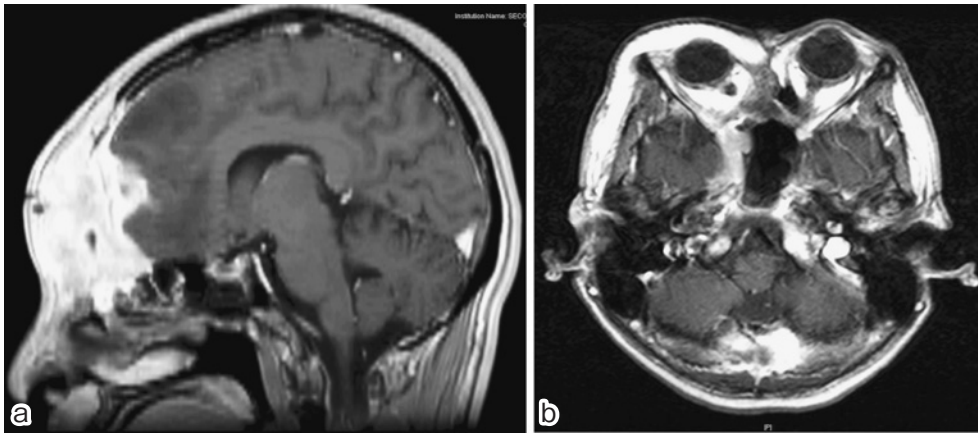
a. Follow-up contrast-enhanced T1-weighted magnetic resonance image from Case 4 shows an enhancing recurrent meningioma. The tumor occupies the right anterior fossa, bilateral ethmoid sinus, right orbit, and frontal sinus.
